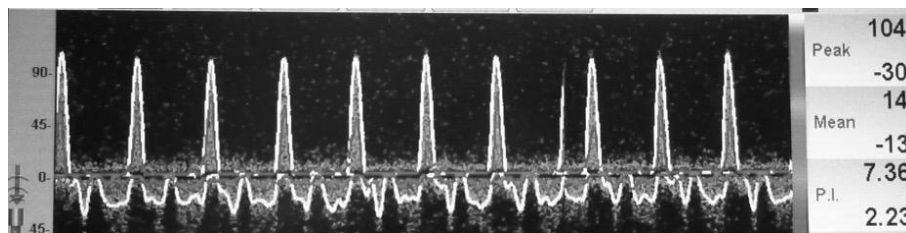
TCD of an 11 year-old boy with meningococcal septicaemia that had neurologic deterioration 48h after admission, showing severe compromise to cerebral blood flow with no diastolic flow. Computed tomography of the brain confirmed severe cerebral oedema.
